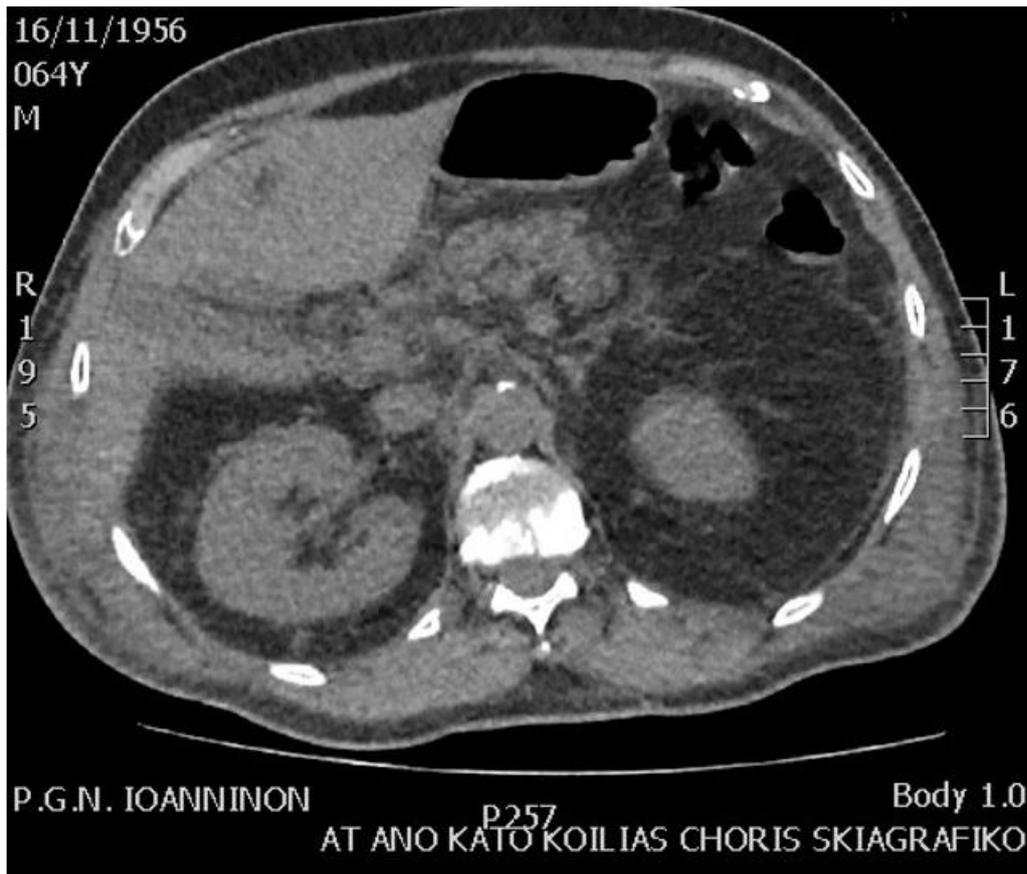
Abdominal computed tomography without radiocontrast shows irregularity of the gallbladder wall.
